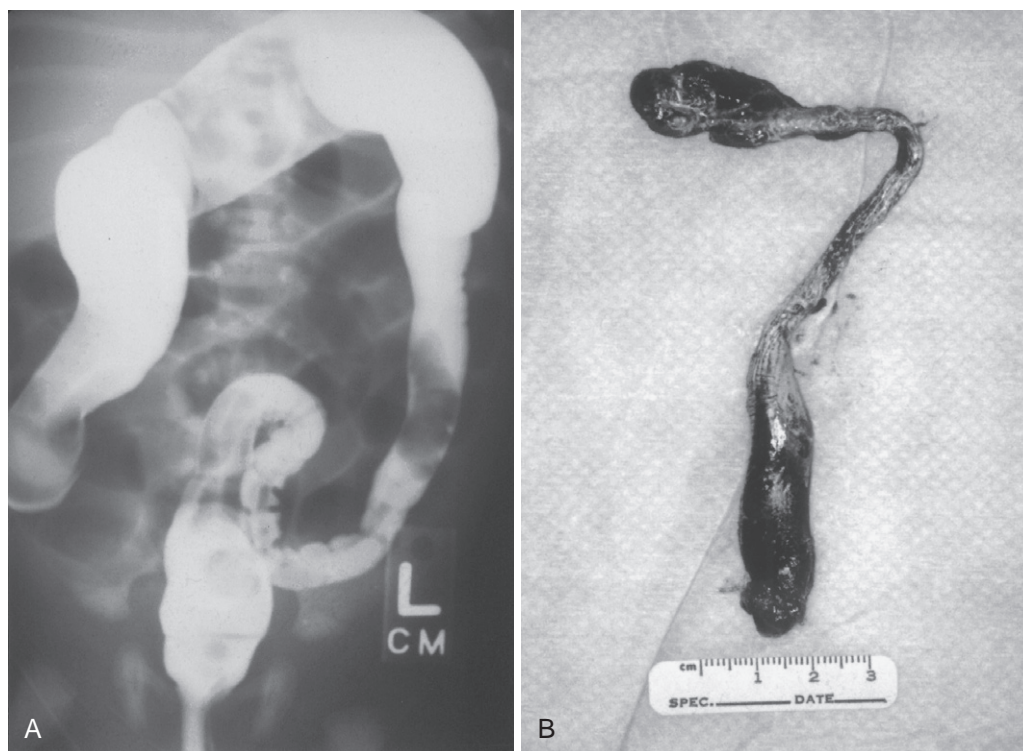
The differential diagnosis of meconium ileus includes several entities characterized by left colon pathology. A, A contrast enema in a newborn presenting with a plain radiographic pattern of a distal bowel obstruction depicts tapering of the colon below the splenic flexure and an intraluminal filling defect in the rectosigmoid colon. These findings would suggest Hirschsprung disease, neonatal small left colon syndrome, or meconium plug syndrome. B, After the removal of the enema catheter, the patient spontaneously passed a “plug” of meconium and the obstruction was relieved. A sweat test and a rectal biopsy may be indicated to exclude the diagnoses of cystic fibrosis and Hirschsprung disease, respectively.
